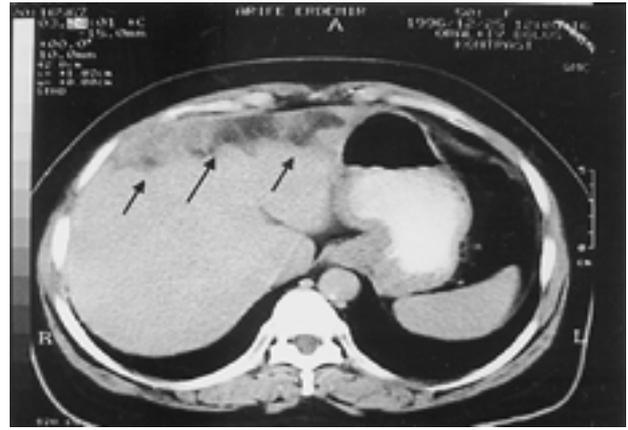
Control CT image (December 1996) : showing the left lobe lesion extending to the anterior surface of the right lobe. The caudate lobe lesion had disappeared.
